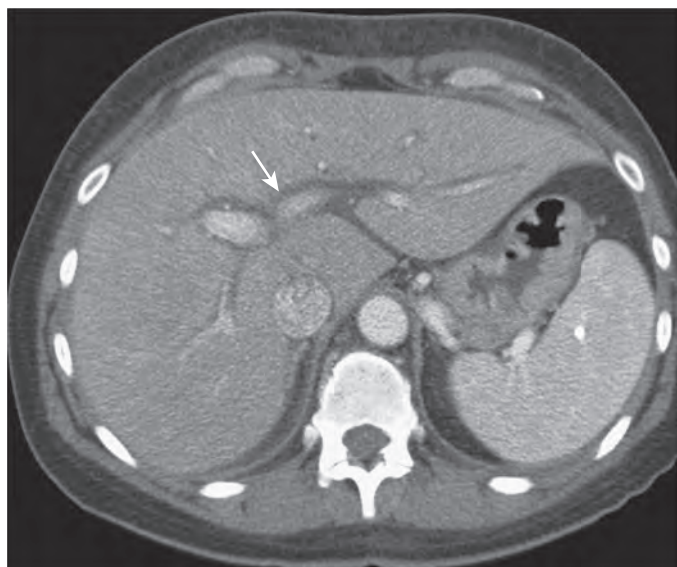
Acute hepatitis: CT findings. CT scan shows periportal edema (arrow) highlighting the intrahepatic blood vessels.
